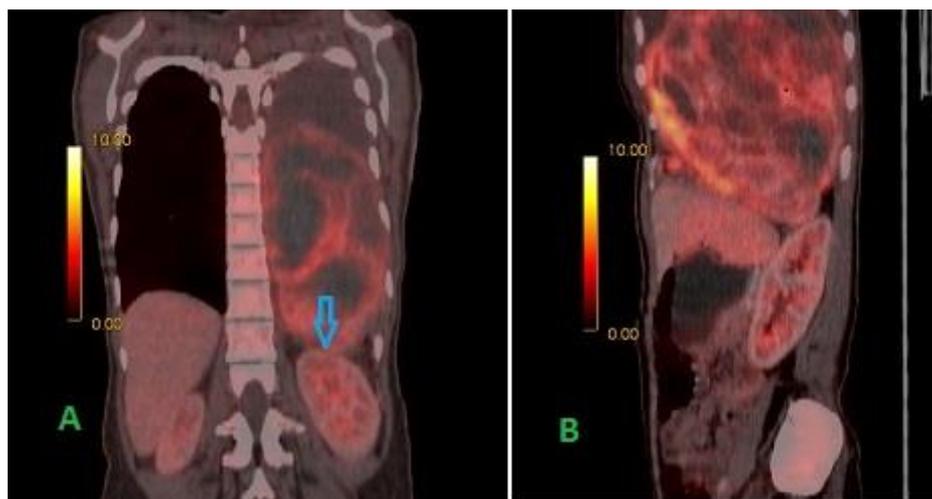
(A): Coronal PET/CT image showing mass in left hemithorax breaching left diaphragm (shown with arrow) causing caudal displacement of left kidney. (B): Sagittal PET/CT image showing mass in left hemithorax with loss of fat plane.
